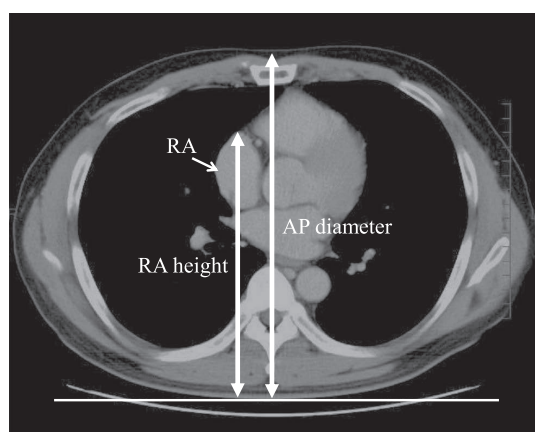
Parameters measured using CT.
